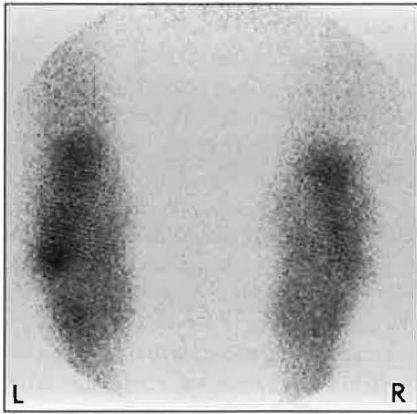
Plantarodorsal scintigraphic view of the bone phase of both tarsi of a 4-year-old Thoroughbred filly.
